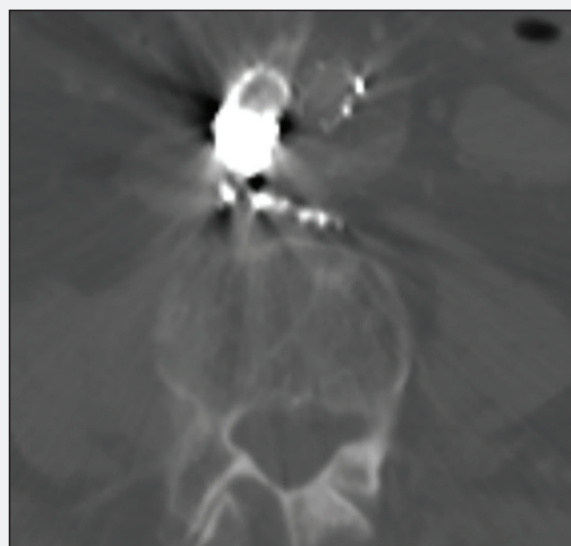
Follow-up CTA showing appropriate position of coil pack and resolution of the endoleak.
